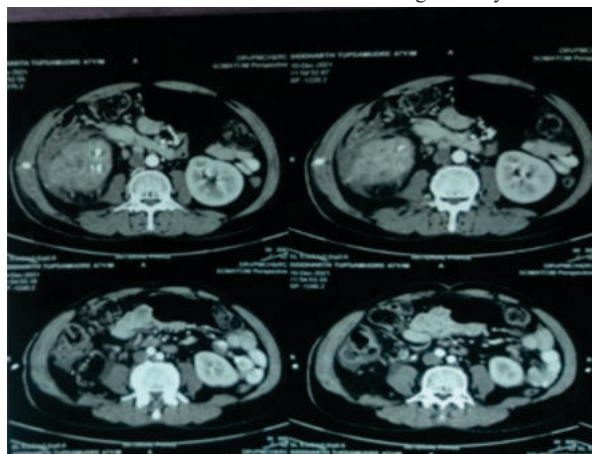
CT Abdomen And Pelvis.
